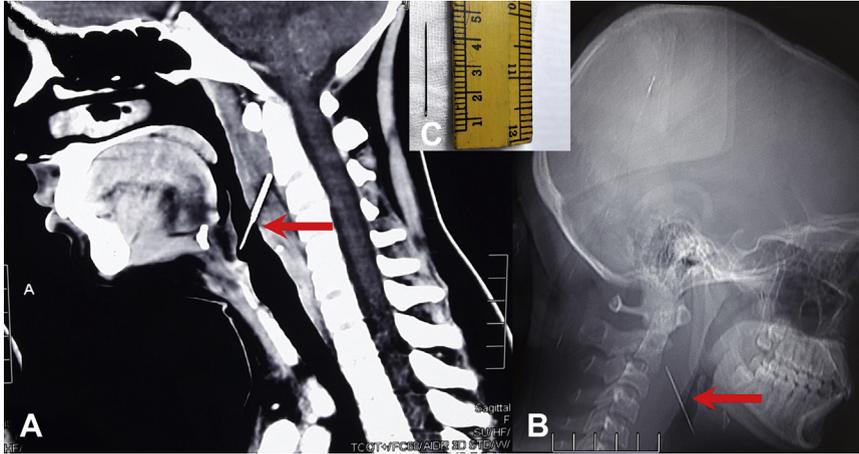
(A) Computed tomography scan and (B) lateral radiograph of neck revealing a linear radiopaque object. (C) The retrieved sewing needle.
